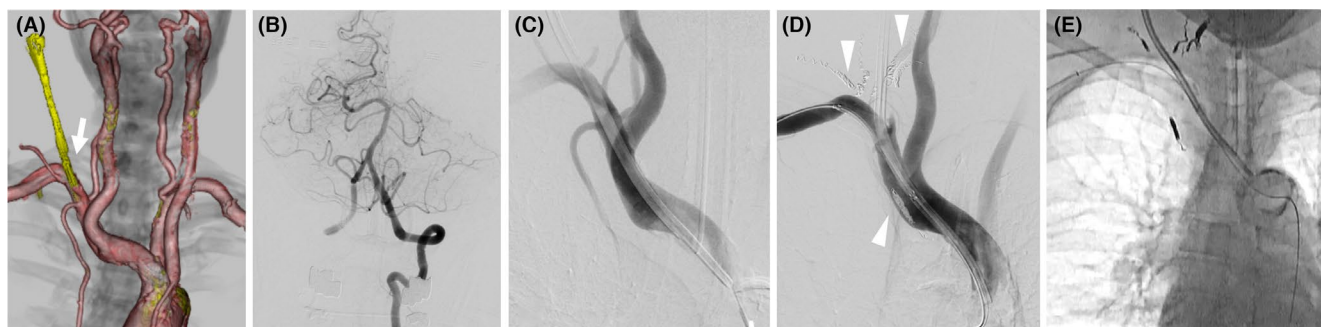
Computed tomography angiography demonstrating inadvertent dialysis catheter insertion into the right subclavian artery (arrow), just distal to the vertebral artery (A). Digital subtraction angiography (DSA) of the left vertebral artery demonstrating adequate perfusion to the entire basilar system (B). DSA image before treatment (C). Occlusion of side branches with coils (arrowheads) to prevent type-II endoleak (D). The pull-through system constructed to advance the stent system without the support of a guiding catheter (E).
